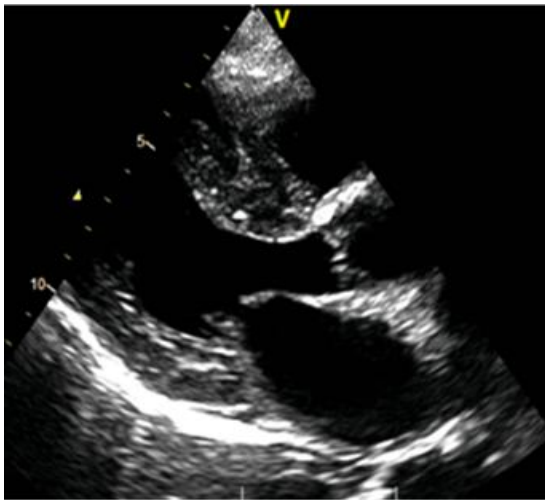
Echocardiogram: left ventricle hypertrophy
